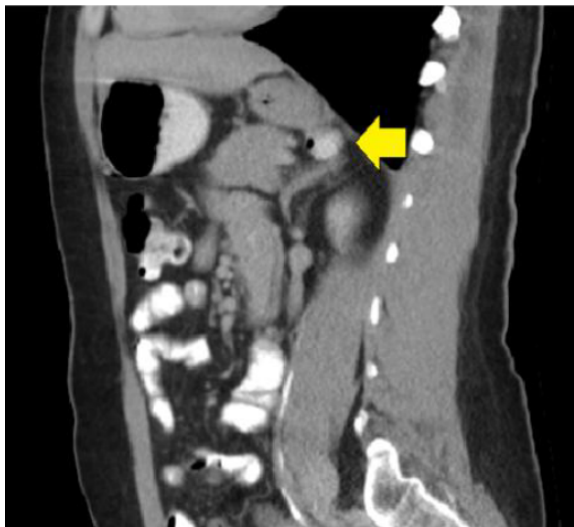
CT-scan-sagittal section observing diverticulum on the posterior wall of the stomach containing contrast medium and air.
